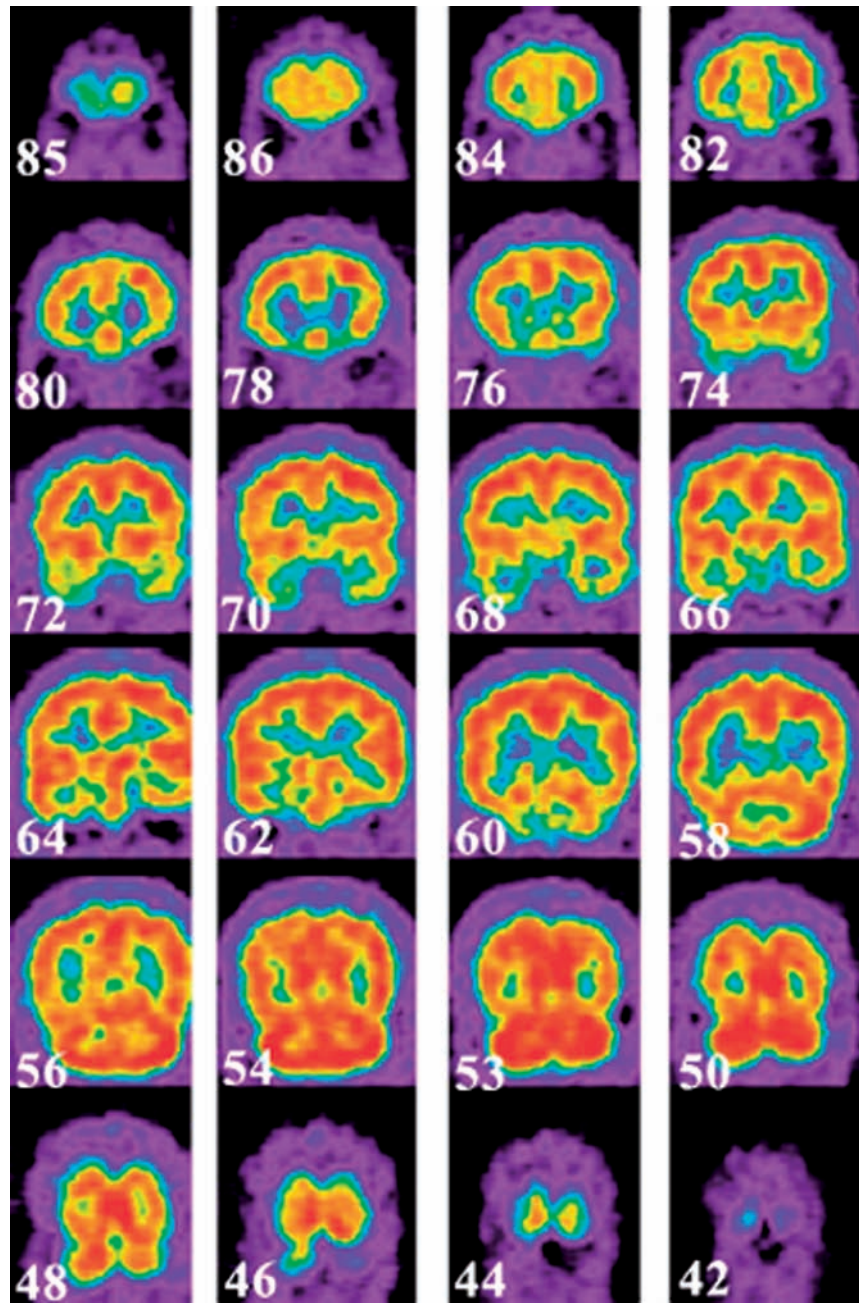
Single-photon emission computed tomography demonstrates increased right cingulate blood flow. See Figures 29.1 and 29.2. Used with generous permission from D.W. Seo (Seo; personal observation).
